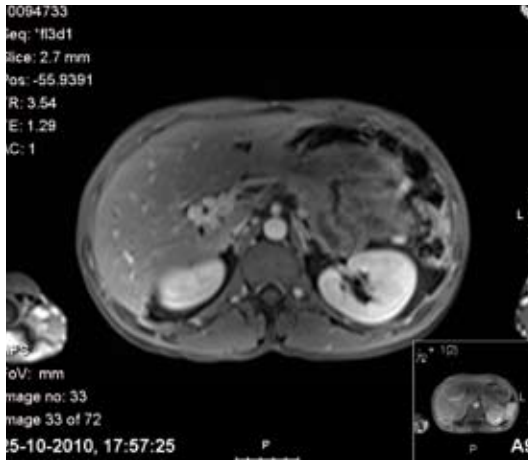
Abdominal - MRI showing cavernous transformation of the portal vein compatible with a chronic portal vein thrombosis.
